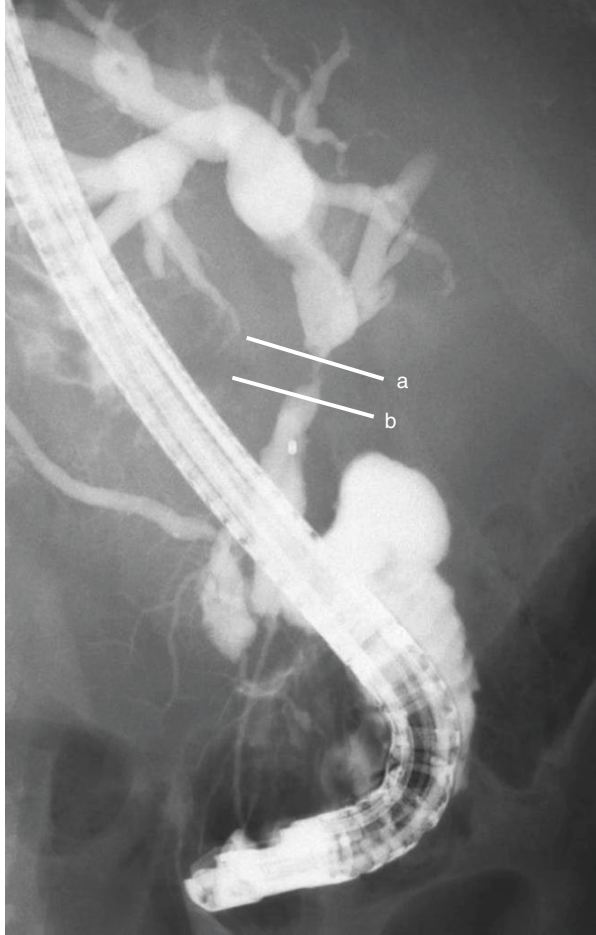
(a) Intraductal ultrasonography (IDUS) depicts carcinoma as a hypoechoic image of irregular thickness. (b) IDUS indicates that the tumor echogram has reached the highly echogenic layer of the bile duct, but not the right hepatic artery (RHA)
